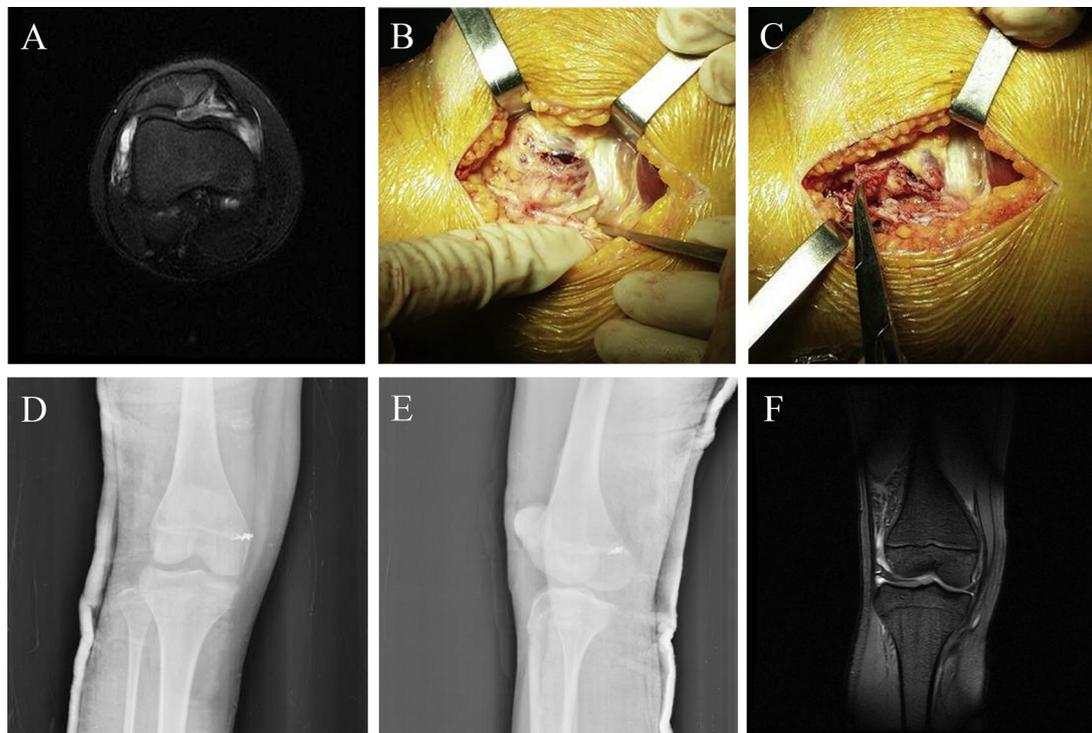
Typical injury patterns with Type IIc MPFL injury are shown. (A) Axial T2 MRI indicates complete MPFL tear at its femoral attachment. (B–C) During operation, a MPFL tear was found, comply with the performance of MRI. (D–E) A minimally invasive operation was performed, thus operative method was responsible for reconstruction of the MPFL. Post-surgical anteroposterior and lateral radiograph views along with a metal anchor at the femoral attachment and cast are shown. (F) No bone marrow edema was seen at the medial patellar facet or the anterolateral femoral condyle.
